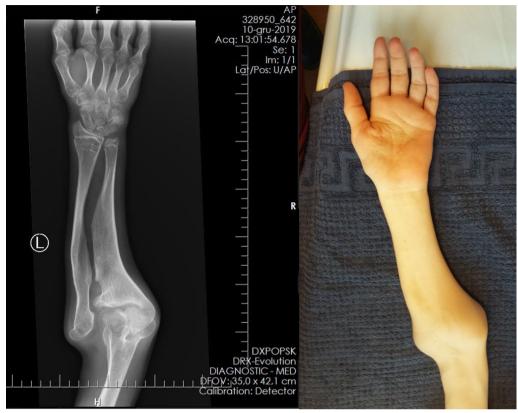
Photograph and X-ray of the left upper limb before surgery
